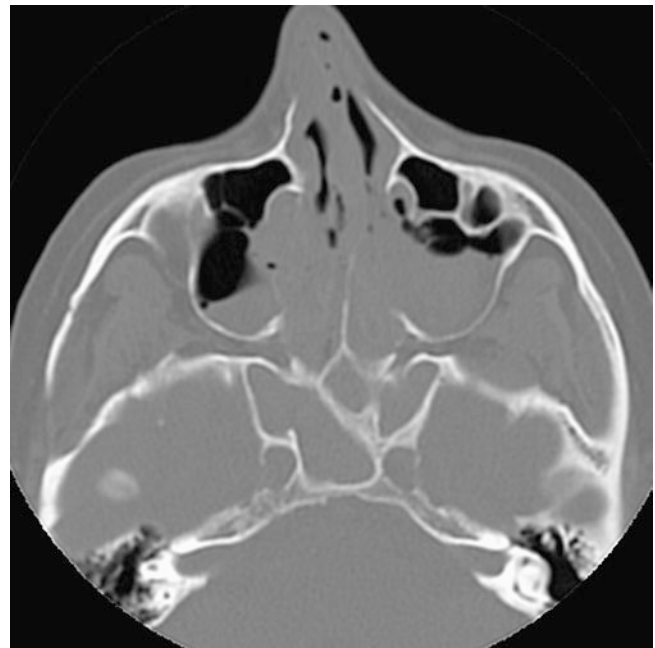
Post-FESS CT scan, axial cut of the same patient as in Fig 30.8 showing gross bilateral bony NLD dehiscence (Courtesy: Ali et al., J Laryngol Otol. 2015;129:35–40)
